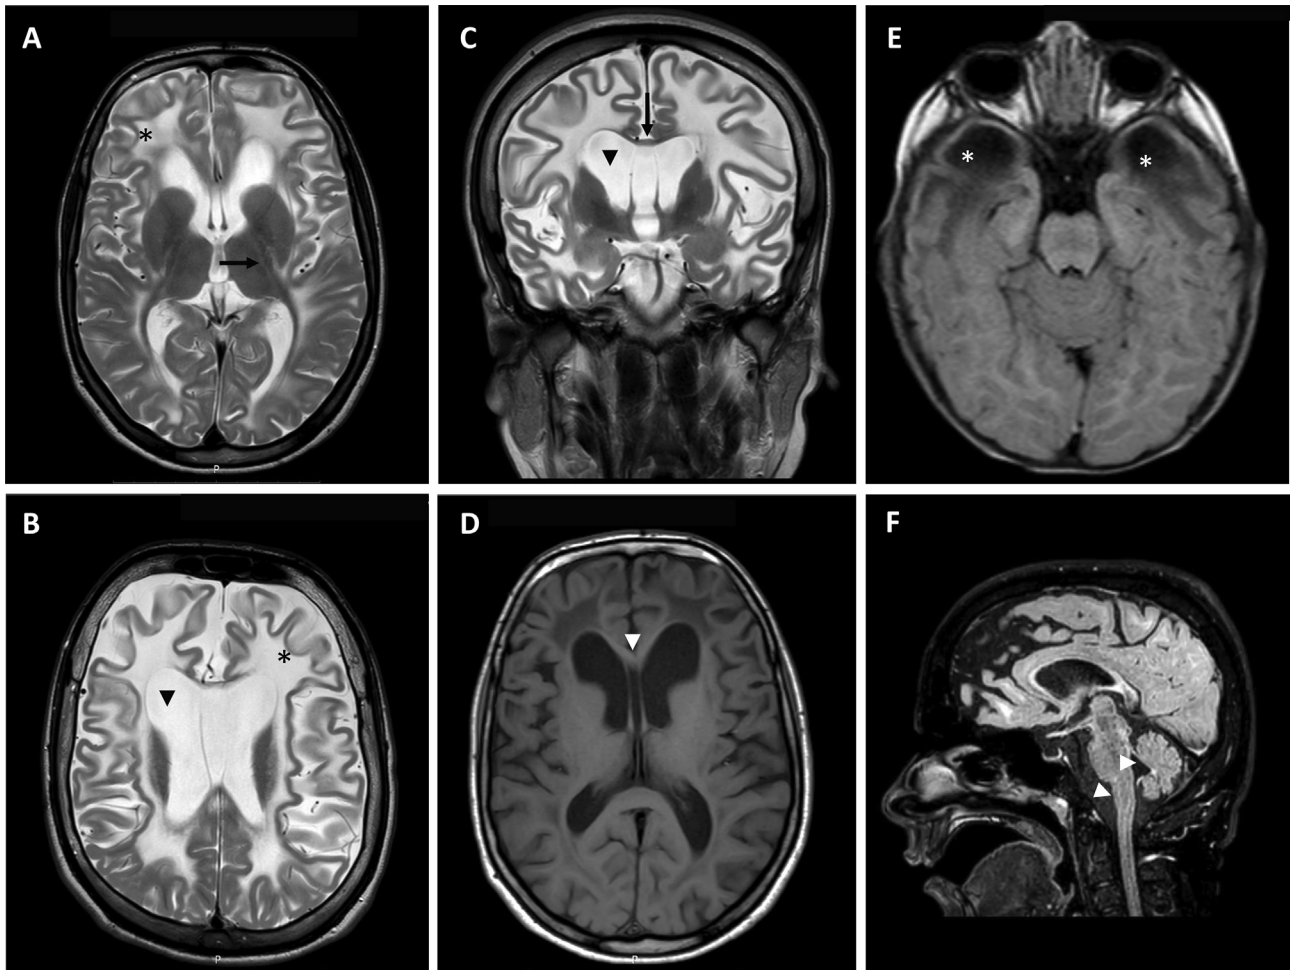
Brain magnetic resonance imaging in MLC patients. MRI for patients from family ii, patient IV:4 (A, D, F), and patient IV:11, (B, C) at the age of 20 and 25 years respectively. MRI for patient VI:1, family (vi) (E) at 4 months of age. Axial T2 sequence shows high-intensity white matter signals involving both cerebral hemispheres, the sub cortical U-fibers (\* in figure A, B), and to a lesser extent the internal capsule (arrow in A) and corpus callosum (arrow in C, arrowhead in D). Coronal T1 sections revealed multiple cysts in the subcortical temporal region (\* in figure E). Exaggerated cerebrospinal fluid spaces at the frontal lobes and enlarged anterior lateral and third ventricles were more prominent with advancing age (arrow in B). Mild atrophy in cerebellar hemispheres, pons, and dilated fourth ventricle were more prominent with time and continued disease progression (arrowheads in F).
